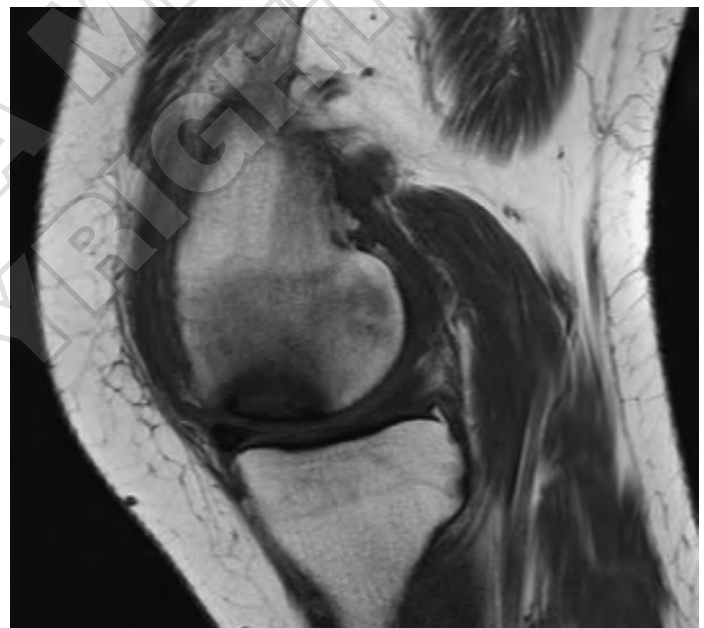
Sagittal T1-weighted MRI in our patient. We can see an osteochondral lesion: an area of low signal intensity (hypointense), corresponding to Osteonecrosis of the femoral condyle.
